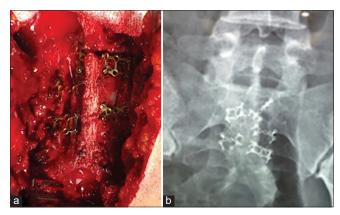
(a) Intraoperative photograph showing reconstruction of the sacrum with mini plate, (b) postoperative sacral X-ray ap view shows the reconstructed sacrum with mini plates.
